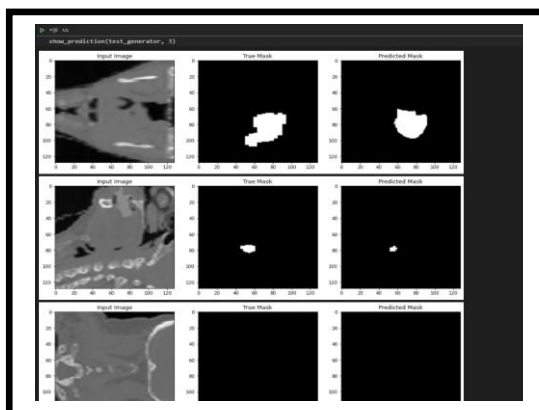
Qualitative results of Cancer cell detection in 3 different patients using 3D GAN. From left to right, 1st image(s) are the input CT Image, 2nd image(s) are the Given mask for the Cancer cell and the 3rd image(s) are the Predicted mask.
